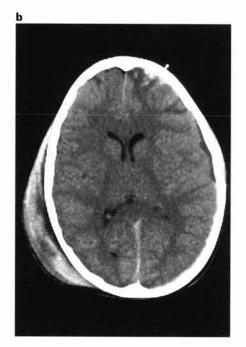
a CT scans of a 9-year-old boy who fell from a second story window, striking his head on cement. Acute study, showing a shallow but extensive left-sided extraaxial hemorrhagic collection with subarachnoid extension. Skull fractures and bilateral frontal and temporal contusions were seen in addition to a right scalp hematoma. b Follow-up scan 1 day afer injury. The contusions persist, but the extra-axial collection has largely resolved without evacuation. There is some persistence of mass effect.
